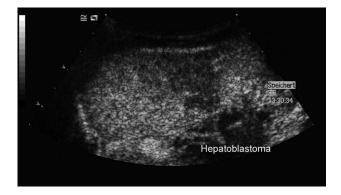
Hepatoblastoma in a 2-year-old boy using contrast-enhanced ultrasound with SonoVue. The malignant nature of the tumor is shown by portal venous hypoenhancement.
